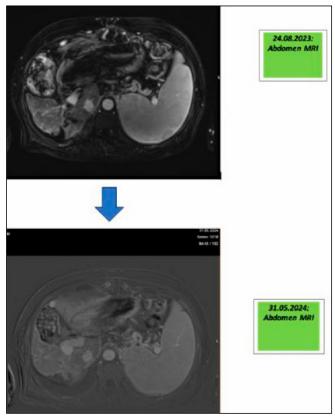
August 2023 - May 2024 Abdomen MRI comparison
